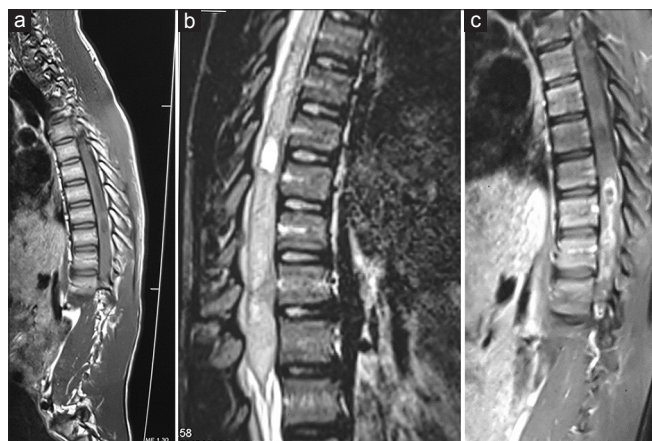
MRI findings: sagittal T1-weighted (a) and T2-weighted (b) and T1 post contrast (c) weighted sagittal images of a dorsal intramedullary GBM from Th9-L1. Note then large conus medullaris in a prominently widened spinal canal. Diffuse, inhomogeneous tumor enhancement and reactive cord edema were seen on the enhanced MR (c)
